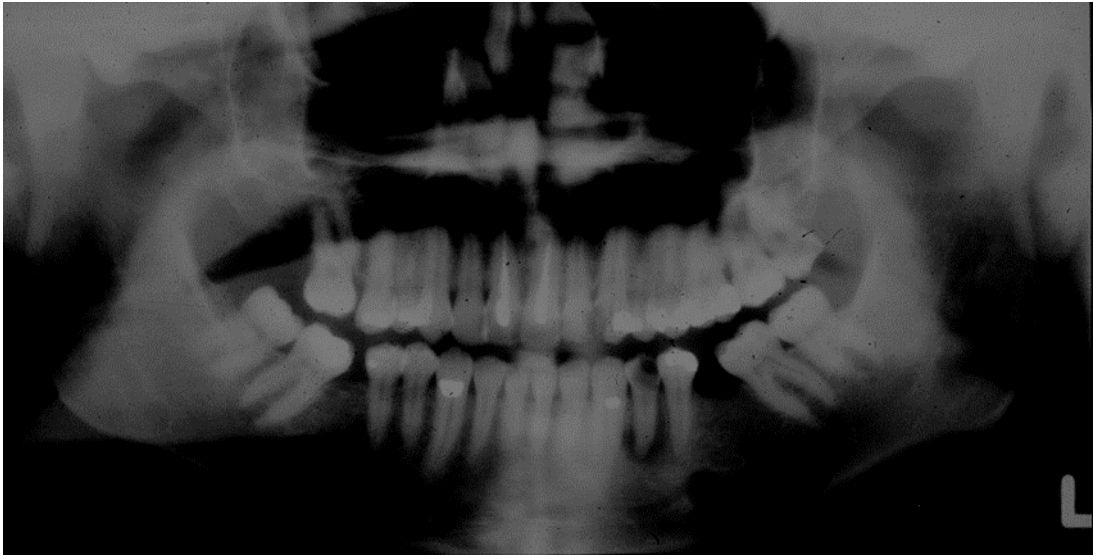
Radiograph shows image distortion due to patient movement during exposure.
